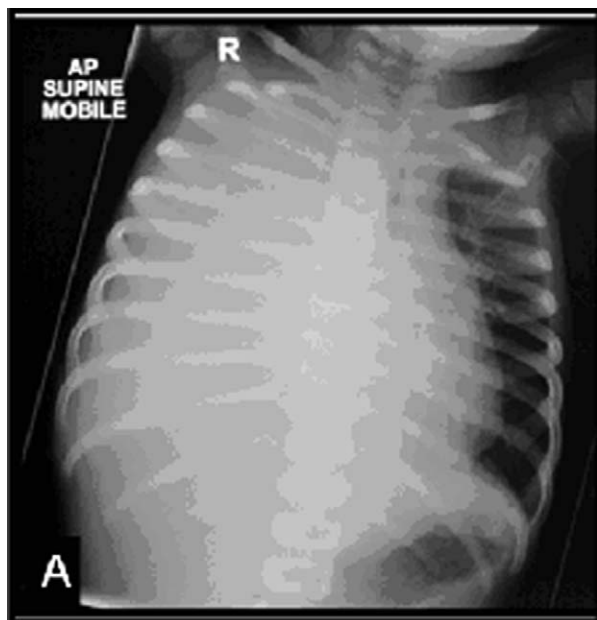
Chest x-ray done on day of admission showing a complete opacification of the right hemi-thorax with mediastinal shift to the left. Figure reproduced with permission from the Med J Aust.⁹
